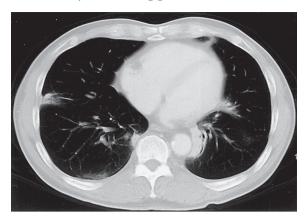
X-ray computed tomography of the chest showed disappearance of consolidation after fludarabine phosphate therapy.
